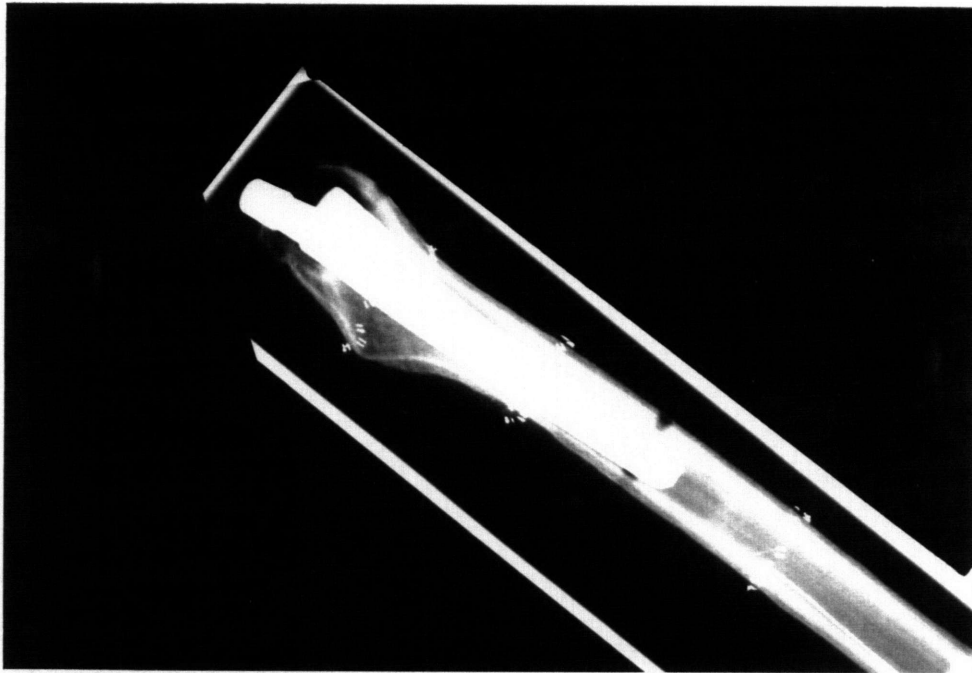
Radiographs showing the position of the prosthesis in bone 2 from (a) medial-lateral and (b) anterior-posterior views.
